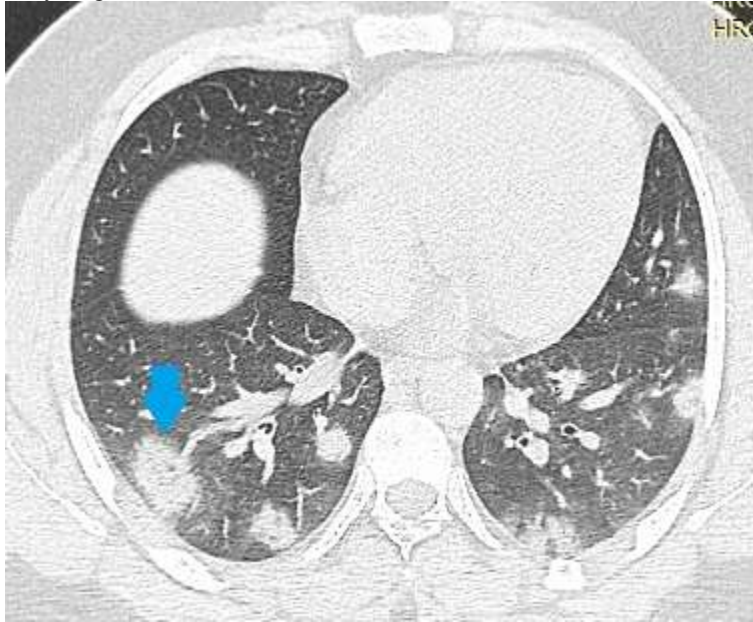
Axial HRCT Chest Image at the level of heart shows an ill-defined area of ground glass opacification in right middle lobe (Hollow black arrow).
